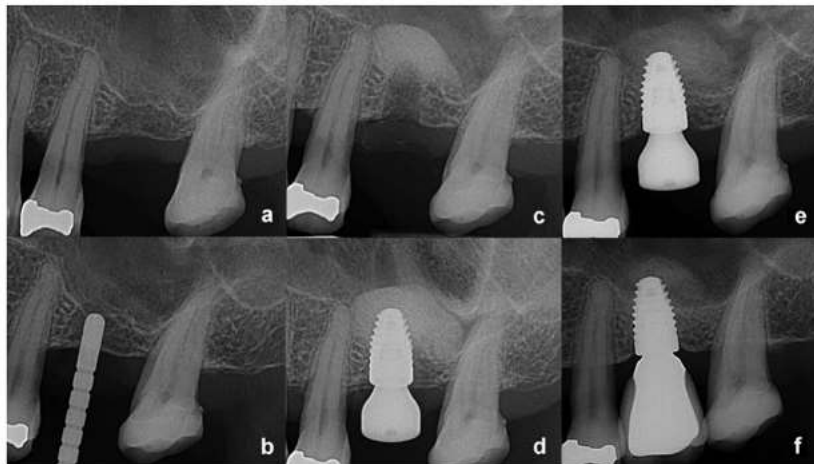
Periapical radiographs demonstrating case 1 (a) preoperative condition, (b) direction indicator pin prior to sinus infracture, (c) after membrane elevation, (d) immediately after implant insertion, (e) 10 weeks post implant insertion, and (f) 10 months post implant insertion
